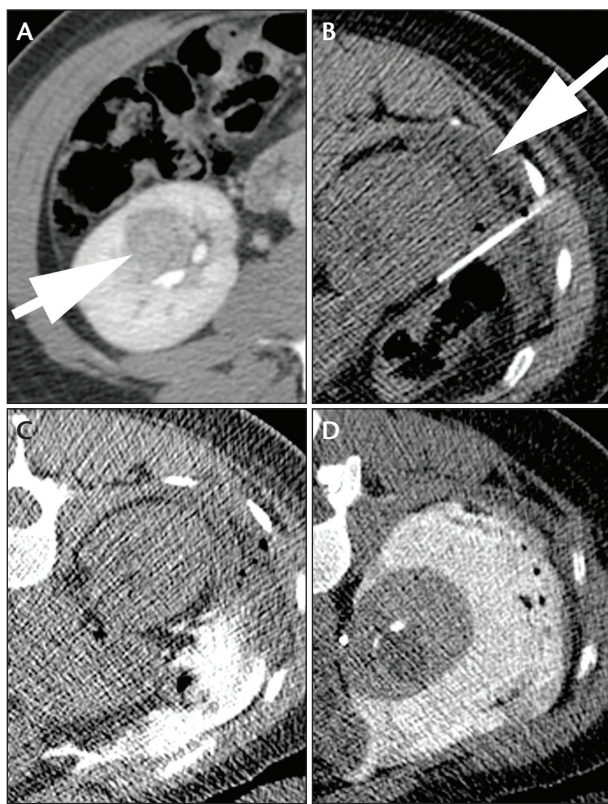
Contrast-enhanced CT image of the enlarging right renal mass (A, arrow) with < 1 cm distance between anterolateral tumor margin and the hepatic flexure of the colon. Initial instillation of normal saline hydrodissection fluid (B, arrow) into the pararenal space did not result in separation between the right kidney and bowel. Therefore, a 22-gauge needle was advanced into the fat between the right kidney and the hepatic flexure. Hydrodissection fluid (now using 3:100 dilution of Omnipaque 350 [GE Healthcare] contrast media in normal saline) instilled with the needle in this location pooled dependently in the peritoneum (C). The 22-gauge needle has been repositioned (D) into a seemingly less advantageous position with tip adjacent to the kidney rather than between the kidney and adjacent bowel. However, fluid instilled through the needle in this position accumulated in the perirenal space and created separation from adjacent bowel.
